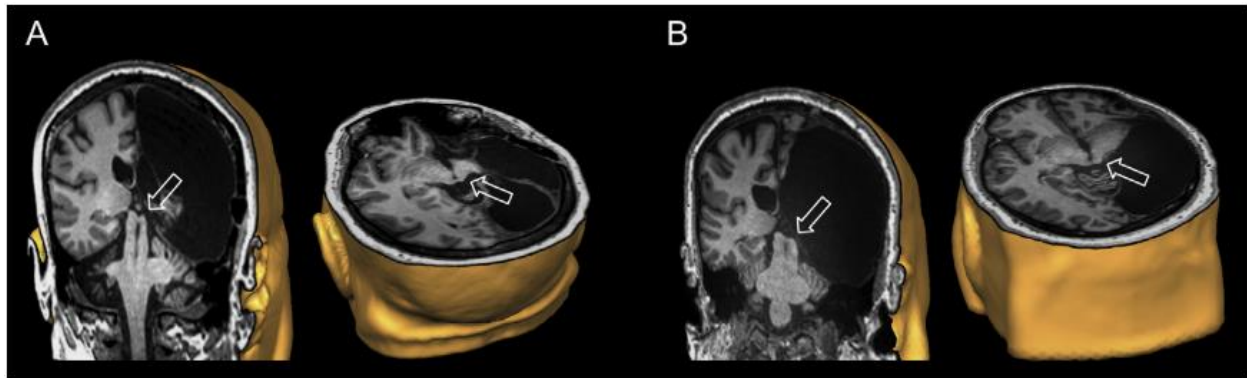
Patient DR and SE T1-weighted MRI
